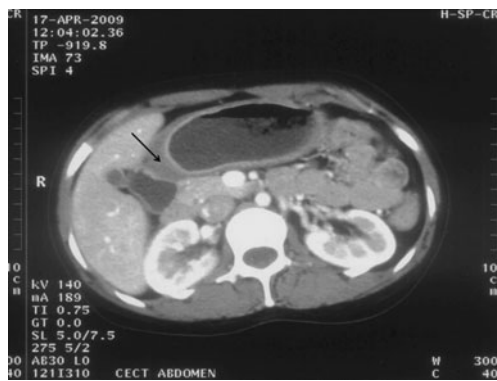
CE CT of the abdomen showing thickening of the antroduodenal area (*arrow*)
